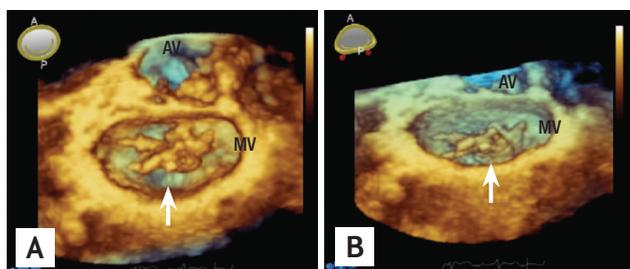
(A) En-face view of mitral valve with a vegetation attached to both anterior and posterior leaflets. Arrow indicates vegetation. (B) The same vegetation in (A) after rotation of the image and showing its complete morphology and spatial orientation, which could only be assessed with 3-dimensional echocardiography. AV, aortic valve; MV, mitral valve.
